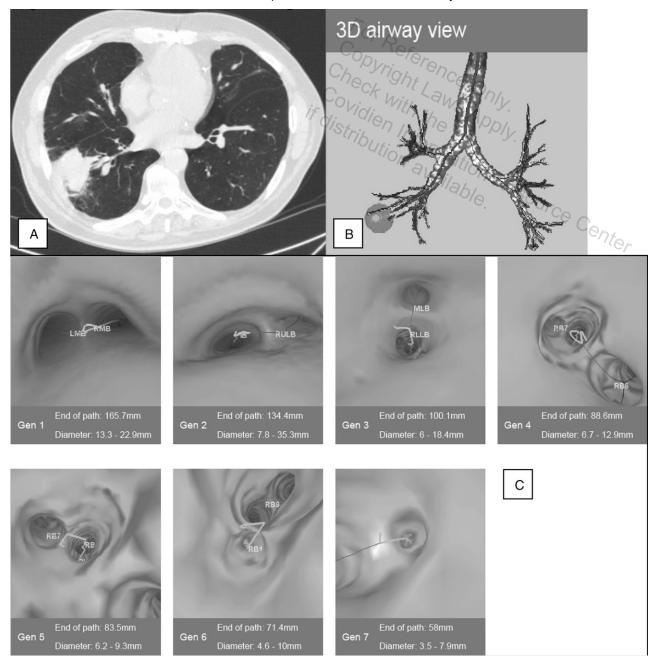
A, Chest CT image of a right lower lobe pulmonary lesion in a 78-year-old smoker. B, 3-D reconstruction of the tracheobronchial tree with the nodule outlined. C, Airway reconstruction of the pathway to the peripheral lesion. (Figure created and provided by Broncus Technologies, Inc.) Gen = generation; LMB = left mainstem bronchus; MLB = middle lobe bronchus; RB = right bronchial; RLLB = right lower lobe bronchus; RMB = right mainstem bronchus; RULB = right upper lobe bronchus.
